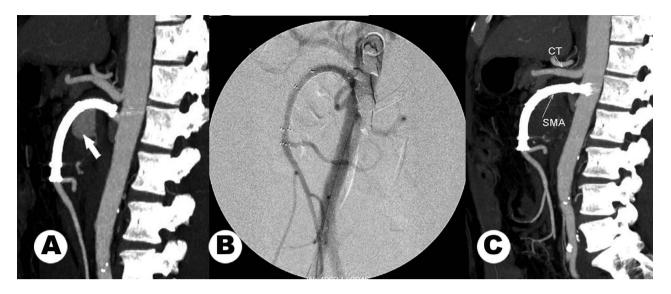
(A) Computed tomography angiography scan showing a sign of endoleak (arrow) 2 weeks after the intimal stent graft implantation. (B) Angiogram after repeat stent graft implantation showing successful sealing of the endoleak with continued patency of the SMA. (C) Computed tomography angiography 1 week after the second procedure showing a patent stent graft without remaining flow in the aneurysm sac.
